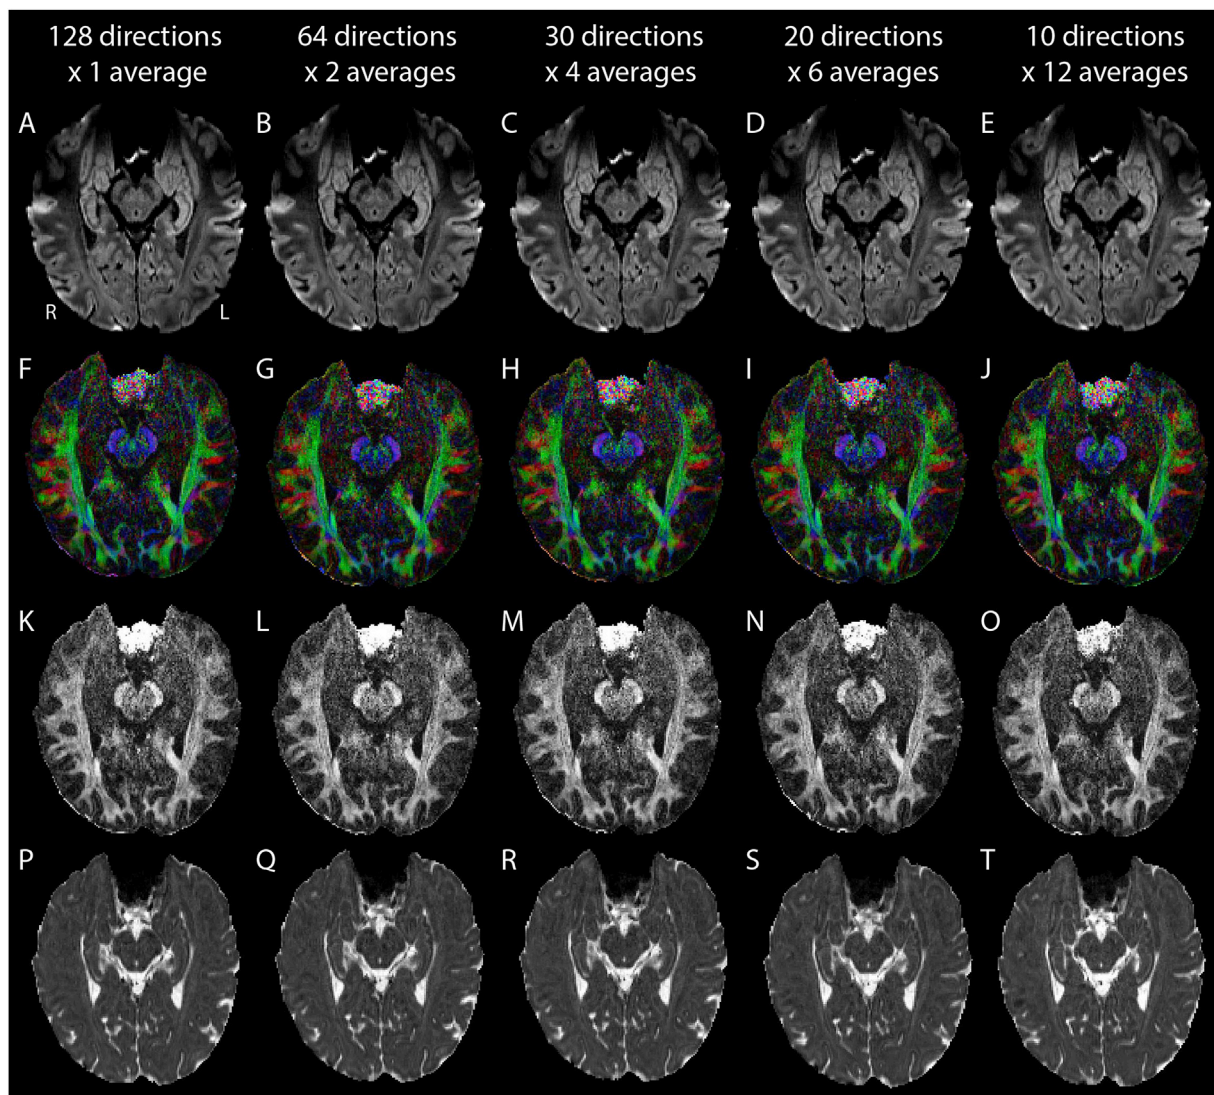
(A–E) Mean 1 mm isotropic diffusion weighted images ($b = 500 \text{ s/mm}^2$), (F–J) FA colour maps, (K–O) FA maps and (P–T) MD maps of a 30 year old male for each of the five acquisitions (listed across the top). Nearly identical contrast is seen in the mean DWI for each acquisition, as expected as they are the average of 120–128 DWIs. Likewise, similar quality parameter maps are produced by all 5 acquisitions, suggesting minimal differences from acquiring a greater number of diffusion encoding directions relative to fewer directions but greater averages.
